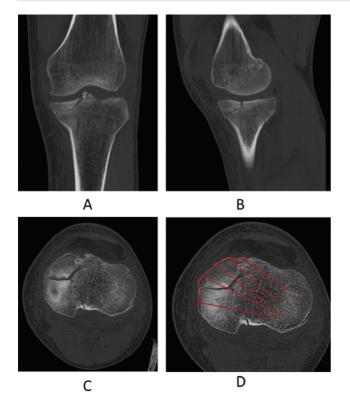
(A-C) Preoperative CT scan of the left knee showing a posteromedial fragment and a small anteromedial articular fragment. (D) Preoperative planning based on CT axial slices, which enables knowledge of the curvatures to make and the length of the screws to use.
